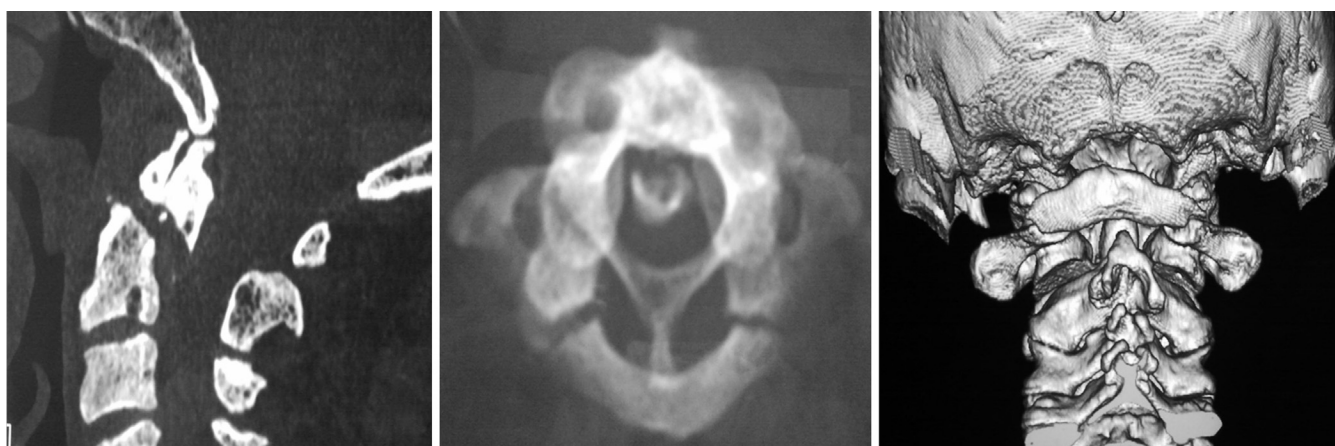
Preoperative radiographs of craniovertebral junction (CVJ) showing rare triad of posterior atlantoaxial dislocation (AAD), Type II odontoid fracture, and fracture of posterior arch of C1 (Left) sagittal CT, (Middle) axial CT, and (Right) 3-D reformatted posterior view.
